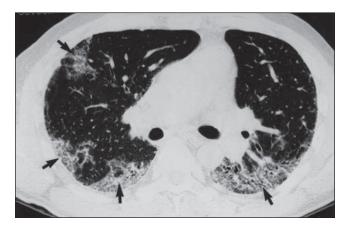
UIP. HRCT demonstrates foci of GGOs in the subpleural regions of the lower lobes (arrows). A few small honeycomb cysts are also present. The central portions of the lung are relatively spared.
